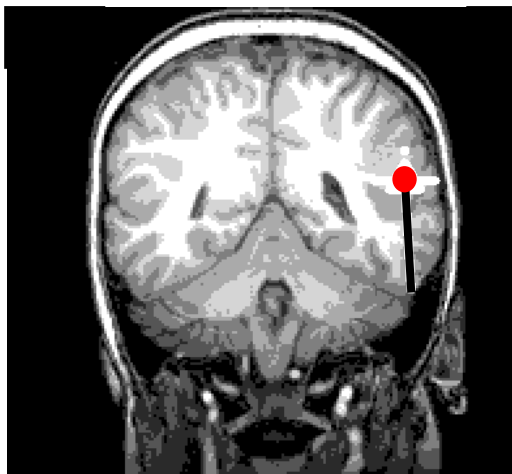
MRI coronal slice with ECD source localization of interictal spike in same patient. Black tail denotes orientation of the current dipole vector. Slice is 0.5mm thick. (Note that the gray scale's utilized for 2DII and ECD differ)
